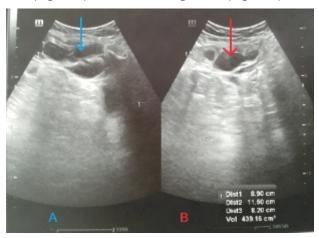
Ultrasound Image showing Left Rectus Sheath Hematoma (Arrows)
